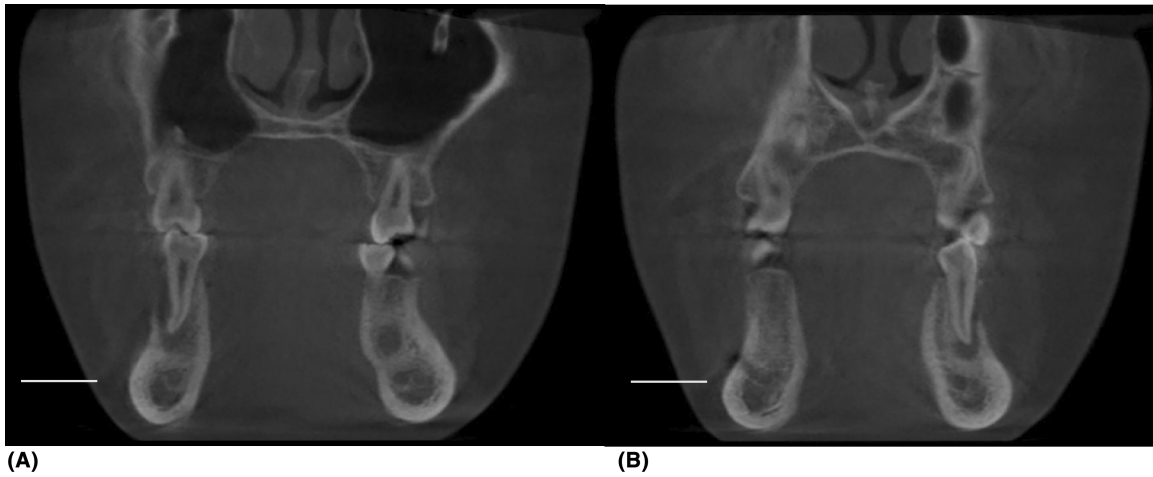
Bilateral buccal plate bone loss evident in coronal view of cone beam CT scan of (A) right and (B) left second mandibular premolars.
